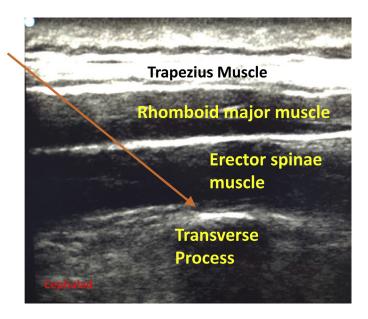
Ultrasound image depicts the anatomy for ESP block. The *orange line* indicates the trajectory of the block needle.
